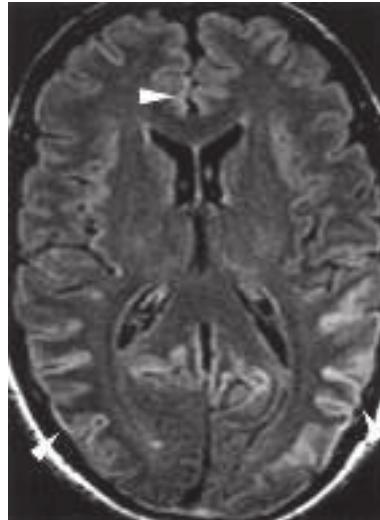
T2-weighted FLAIR MRI showing hyperintensity in the cortex in a patient with sCJD. This so-called cortical ribboning along with increased intensity in the basal ganglia on T2- or diffusion-weighted imaging can aid in the diagnosis of CJD.
